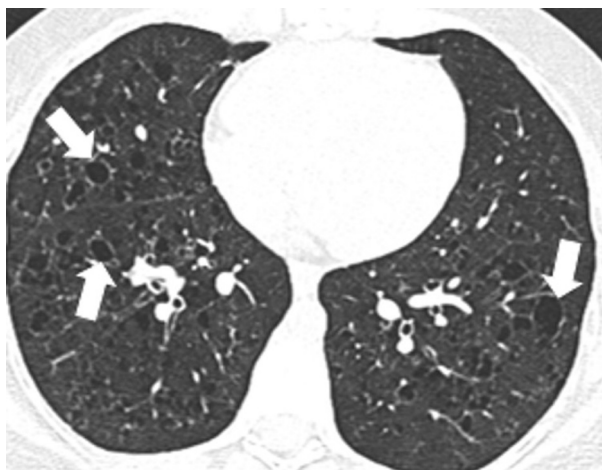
Transverse chest CT scan with diffuse bizarrely shaped thick-walled cysts of varying sizes consistent with pulmonary Langerhans cell histiocytosis.
